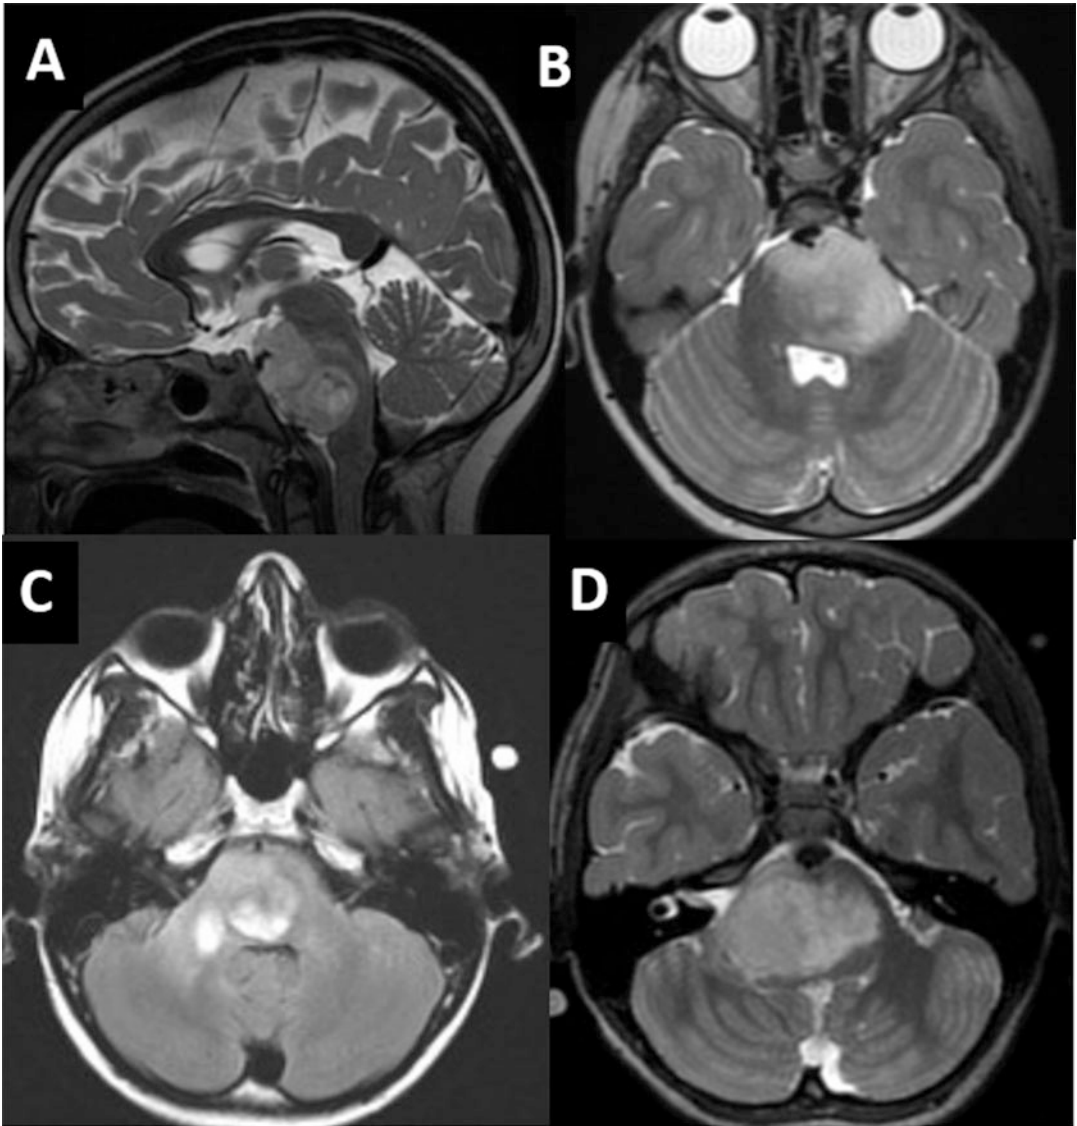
(a) Brain MRI sagittal T2WI showing an expansile pontine mass that abuts the clivus in a 7-year-old girl presenting with hemiparesis; (b, d) encasing the basilar artery in axial T2WI. The actual size and extension
